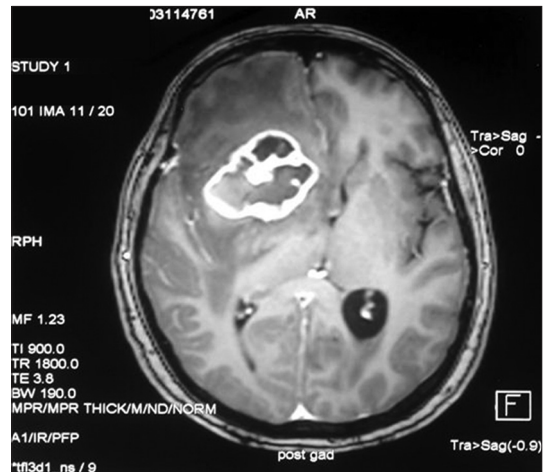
T1 weighted contrast enhanced MRI showing heterogeneously enhancing lesion in Right fronto temporal region with significant perilesional edema and mass effect
